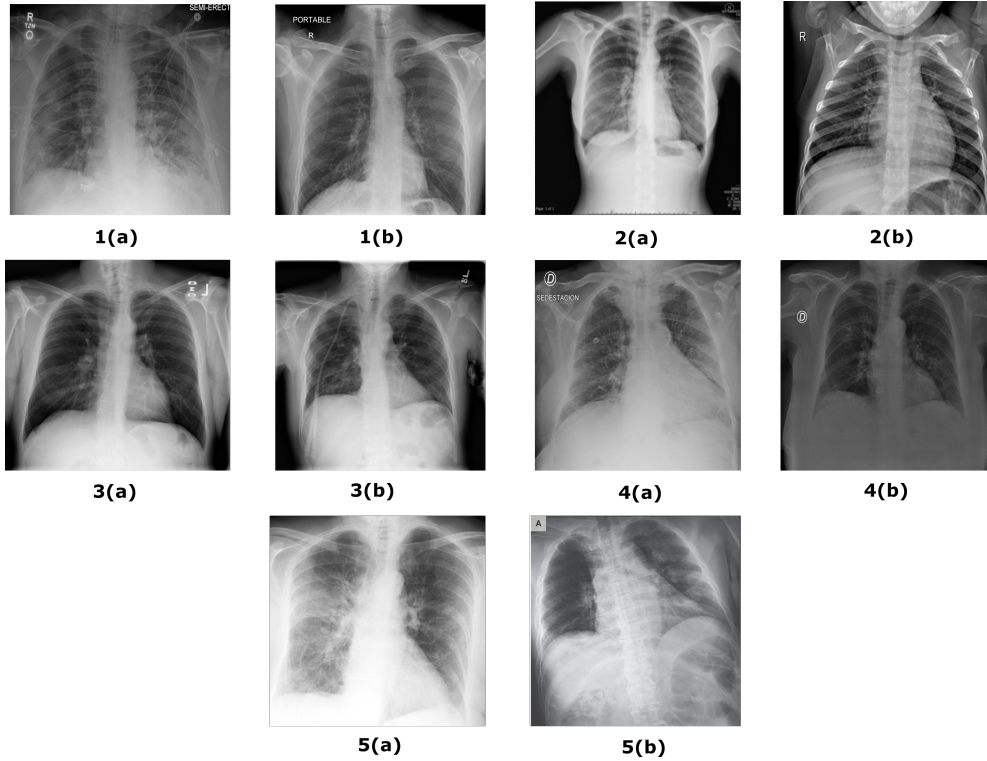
Sample images from COVIDx dataset from multiple repositories, 1. COVID-19 Image Data Collection [7], 2. COVID-19 Chest X-Ray Dataset Initiative[6], 3. RSNA Pneumonia Detection challenge dataset[18], 4. ActualMed COVID-19 Chest X-Ray Dataset Initiative[5], 5. COVID-19 radiography database[17]
